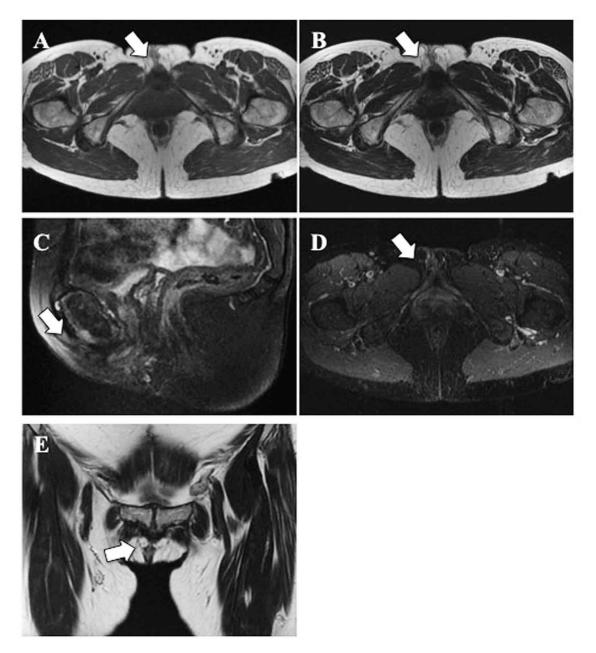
Follow-up MRI at 48 months
